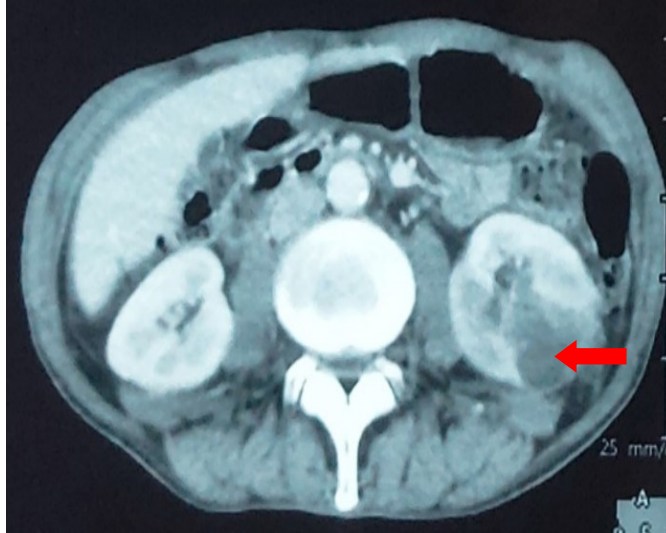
Axial abdominal CT showing a renal mass (red arrow).
